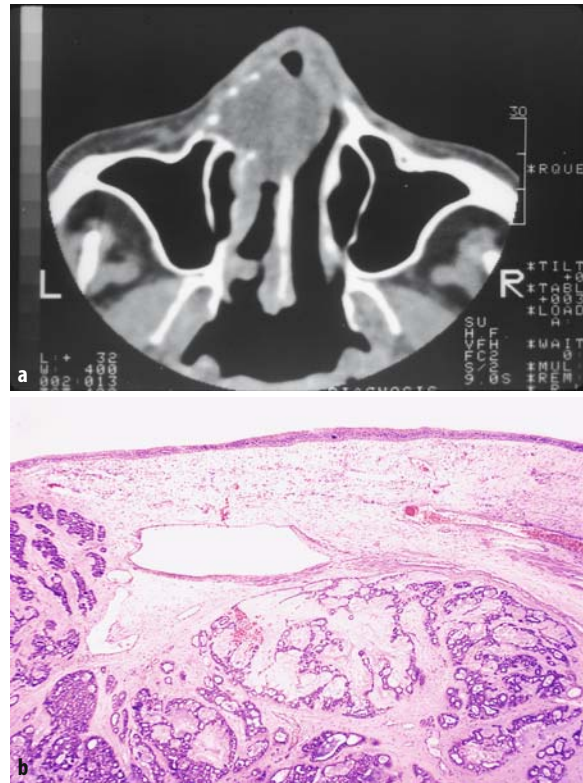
Polymorphous low-grade adenocarcinoma. a CT scan showing an irregularly nodular lesion destroying the anterior nasal septum. Courtesy of Prof. J. Traserria, Barcelona, Spain. b Variegated glandular arrangements composed of tubules with bland cellularity are seen beneath respiratory epithelium
